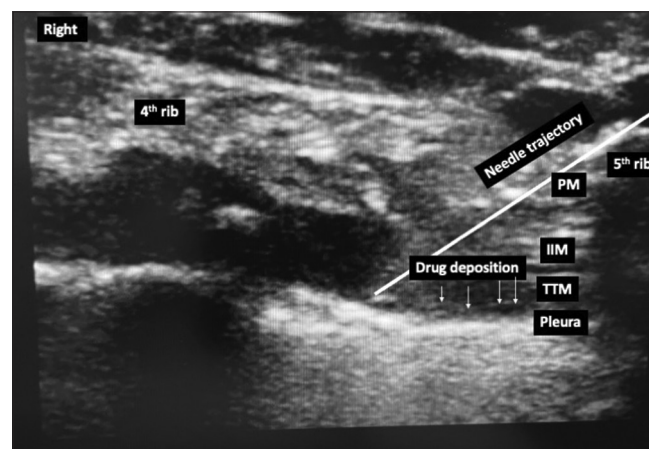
The ultrasound image showing out of the plane technique for Tuohy's needle placement between the inner intercostal and transversus thoracic muscles, depositing the ropivacaine between transverse abdominis muscle and transversalis fascia on the right side (IIM: Internal intercostal muscle; PM: Pectoralis major; TTM: Transversus thoracic muscle)
